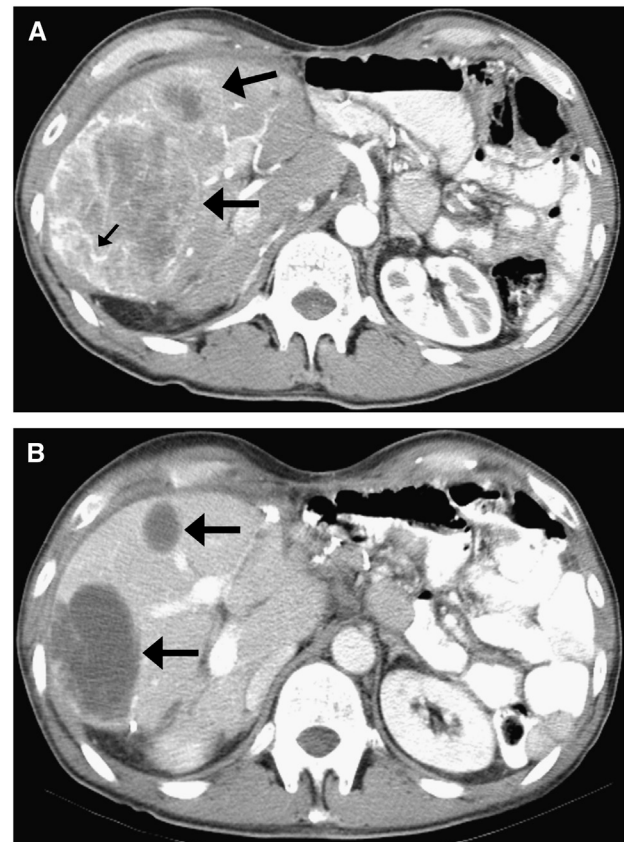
Good response to imatinib treatment in a 50-year-old man with metastatic gastrointestinal stromal tumor of the stomach. (A) A late arterial-phase image of pretreatment CT showed multiple hypervascular metastases in the liver (large arrows). Notice small tumor vessels within the mass (small arrow). (B) On CT obtained 8 weeks after treatment, the masses became hypodense (arrows) and the tumor vessels and enhancing nodules are no longer seen. Courtesy of Haesun Choi, MD, The University of Texas M. D. Anderson Cancer Center.
